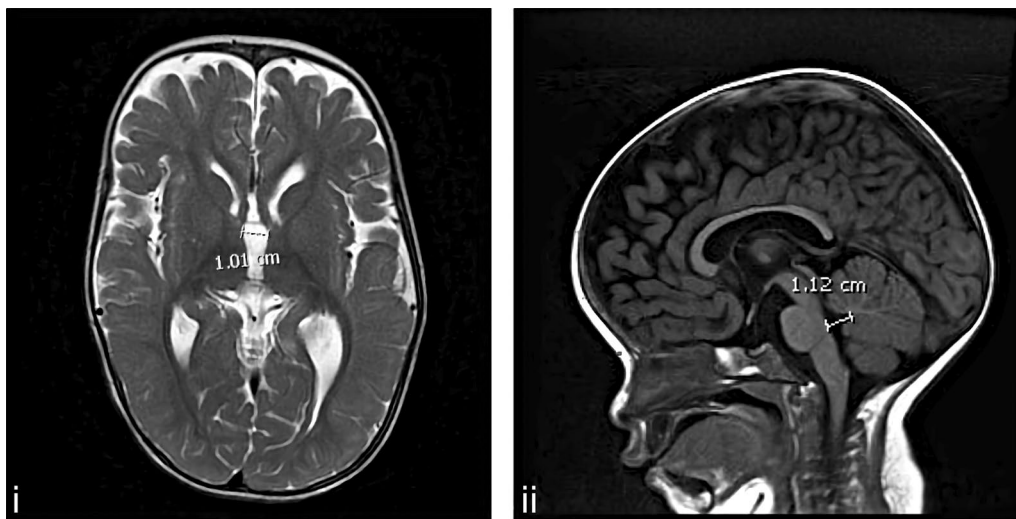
(i) Axial T2 prop. (ii) Sagittal T1 Flair brain MRI: macrocephaly with slight ventricular extra-axial CSF prominence with prominent cerebral sulci and mild-to-moderate white matter atrophy at 12 months of age
